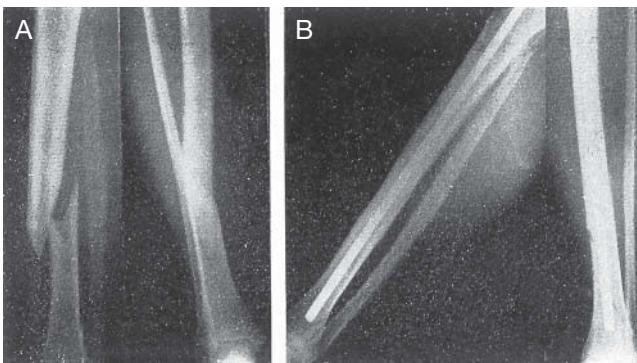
Mrs. H. Open fracture, middle-third of tibia and upper-third of fibula. A: Preoperative x-rays. B: X-ray view at 1 month.
